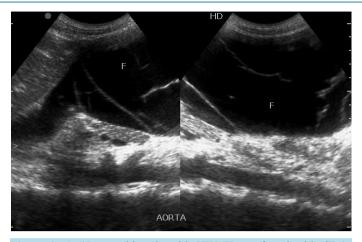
A 45-year-old male with HIV-TB confected with CD4+ T-cell count of 196 cells/mm³ with disseminated tuberculosis. The sonograms show ascites with fibrinous band opacities.
